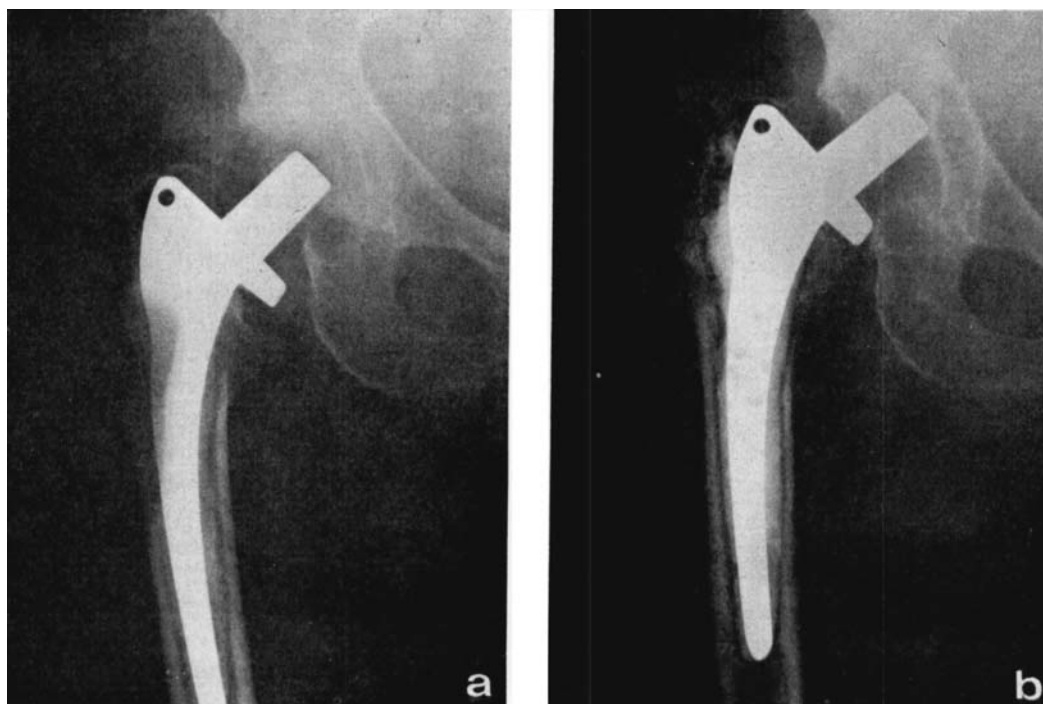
X-rays of the same hip taken 19 months apart. Note reduced distance between the prosthetic neck and the acetabular floor.
